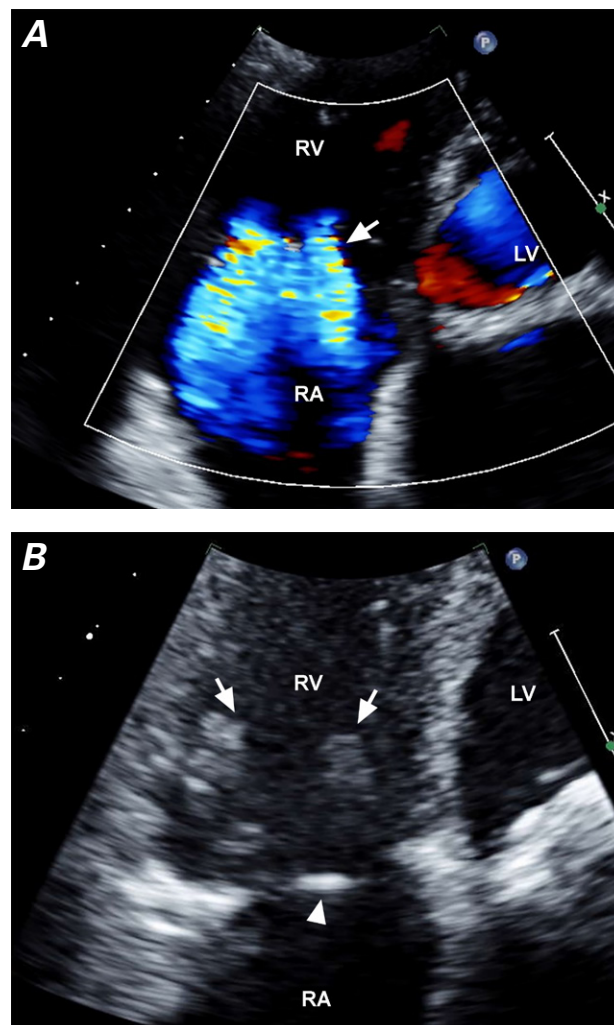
Transesophageal echocardiograms. A) Color-flow Doppler mode reveals moderate-to-severe tricuspid regurgitation (arrow). B) In diastole (4-chamber view), an echodense streak (arrowhead) is visible at the annular level. Arrows point to the tricuspid valve leaflets.
